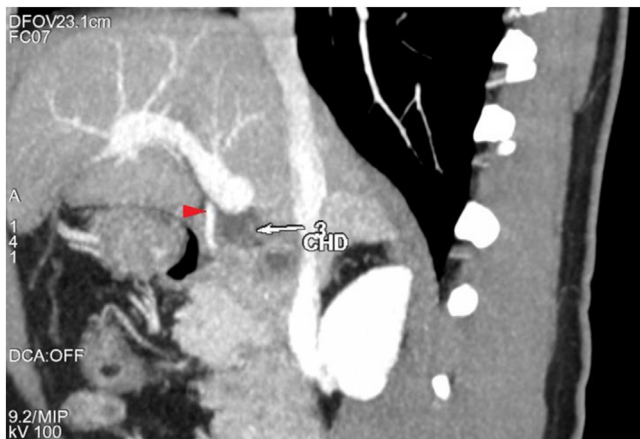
CT Angiography: Sagittal cross-section showing RHA (red arrowhead) passing in front of the CHD.
